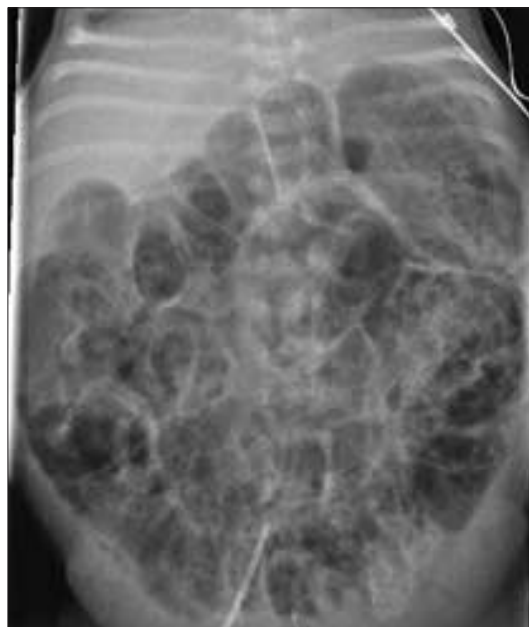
Plain abdominal radiograph of an infant with necrotizing enterocolitis showing intestinal dilatation and extensive pneumatosis intestinalis.
